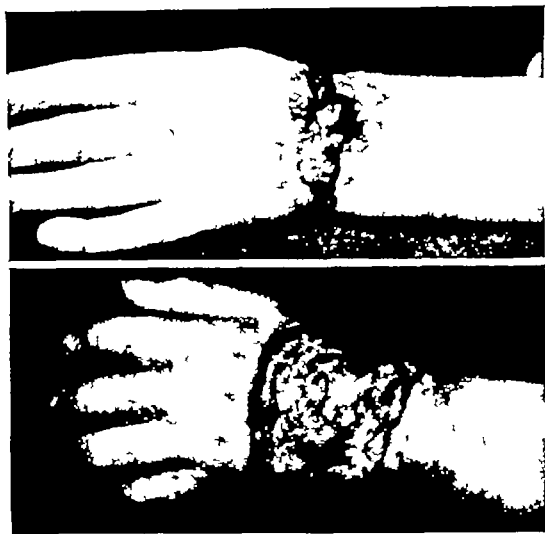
Case 8 Above, carcinoma of dorsum of hand before treatment Note that fingers are essentially normal Below after roentgen therapy The carcinoma has been destroyed, but there is deep necrosis Note the useless fingers Amputation was done
